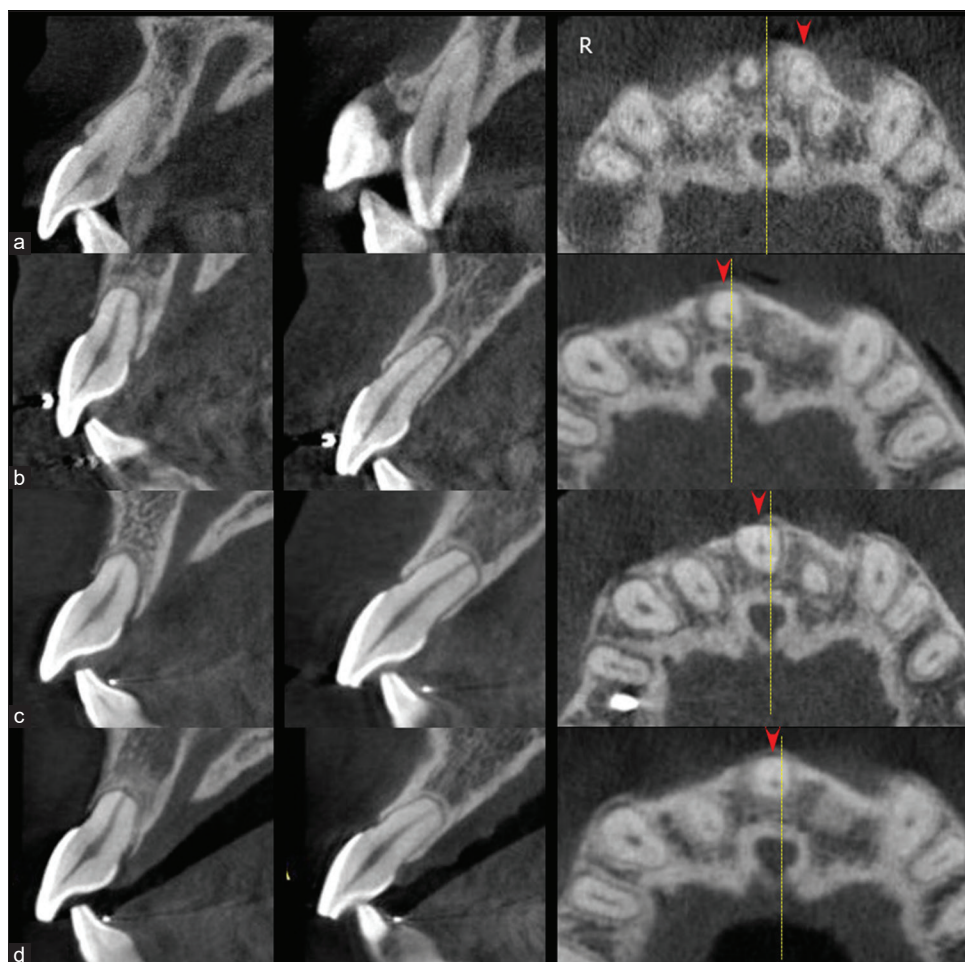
Cone-beam computed tomography sagittal (upper and middle) and horizontal (bottom) images of the maxillary left central and lateral incisors and the maxillary anterior area in the horizontal plane. The red arrowheads indicate the root of the maxillary left central incisor and the yellow broken line depicts the midline that corresponds with the midpalatal suture. (a) Pre-treatment; (b) after completion of the space-closing procedure; (c) post-treatment; (d) post-retention. R: Right.
